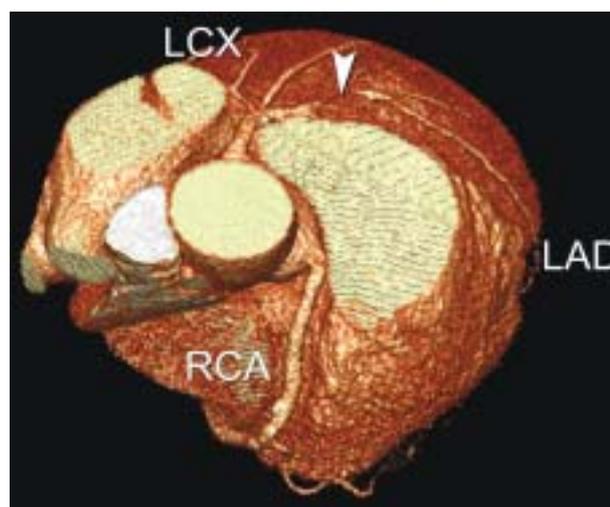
Volume-rendered computed tomography image: 3-dimensional overview of the coronary arteries. Arrowhead: presence of a significant obstructive coronary lesion located in the left anterior descending coronary artery (LAD). LCX, left circumflex coronary artery; RCA, right coronary artery.
